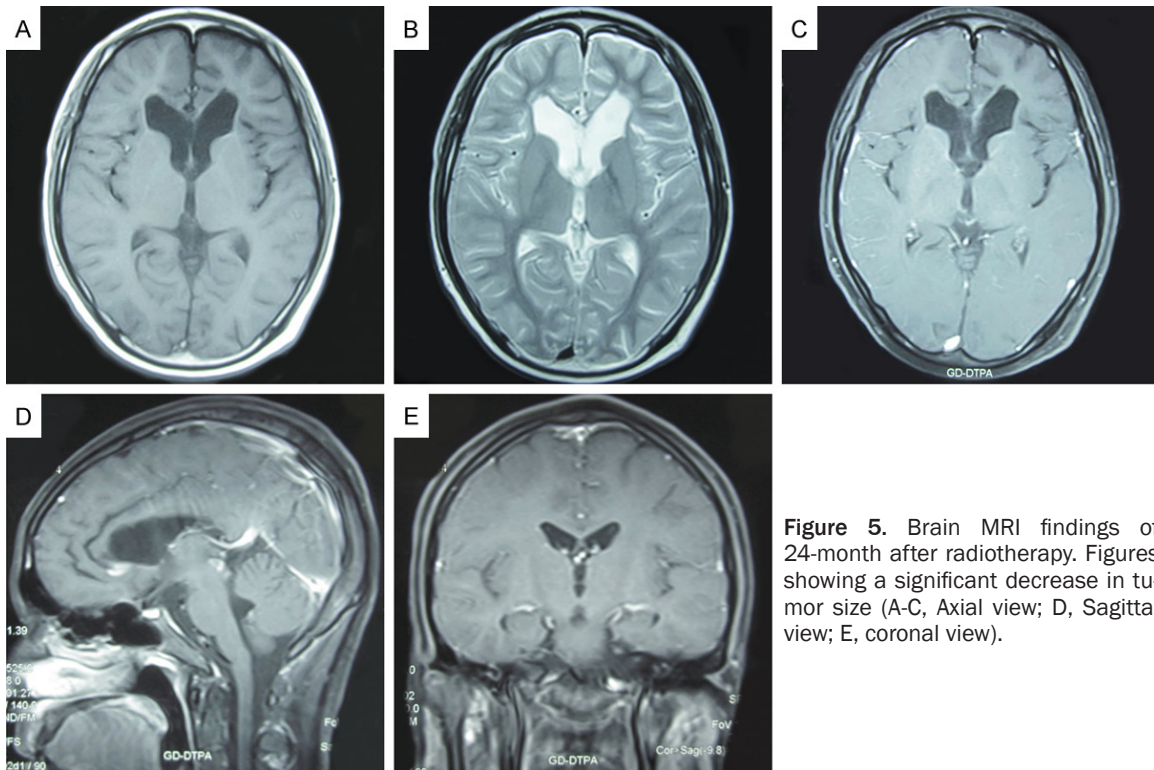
Brain MRI findings of 24-month after radiotherapy. Figures showing a significant decrease in tumor size (A-C, Axial view; D, Sagittal view; E, coronal view).
